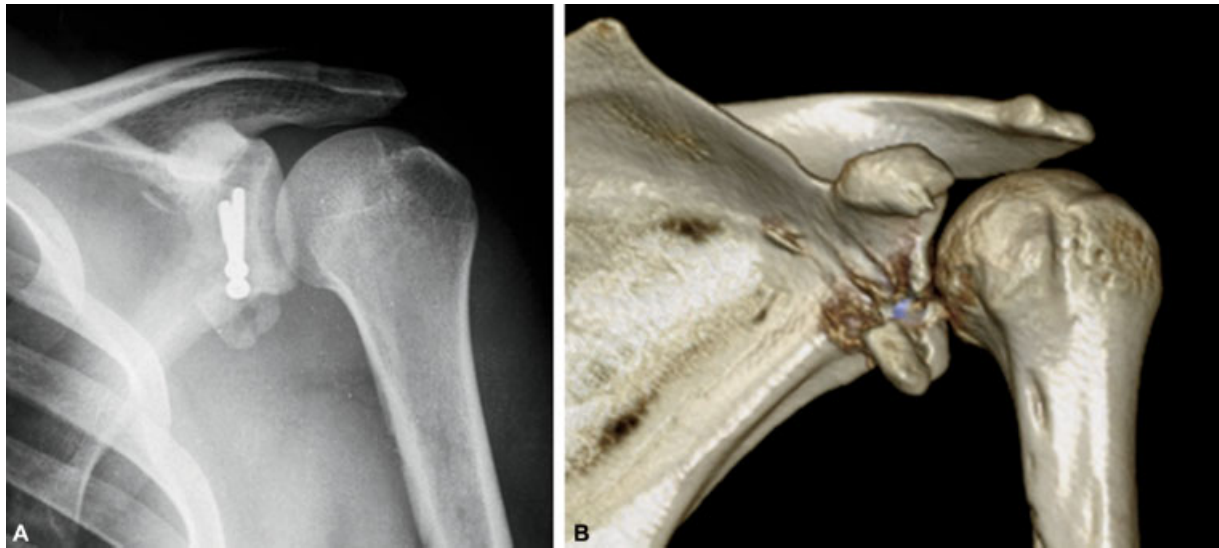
Radiography (A) and three-dimensional computed tomography scan (B) 3 weeks after surgery showing graft fracture.
